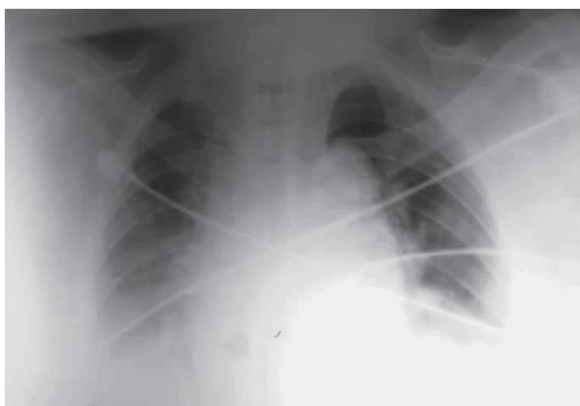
Chest X-ray upon admission
